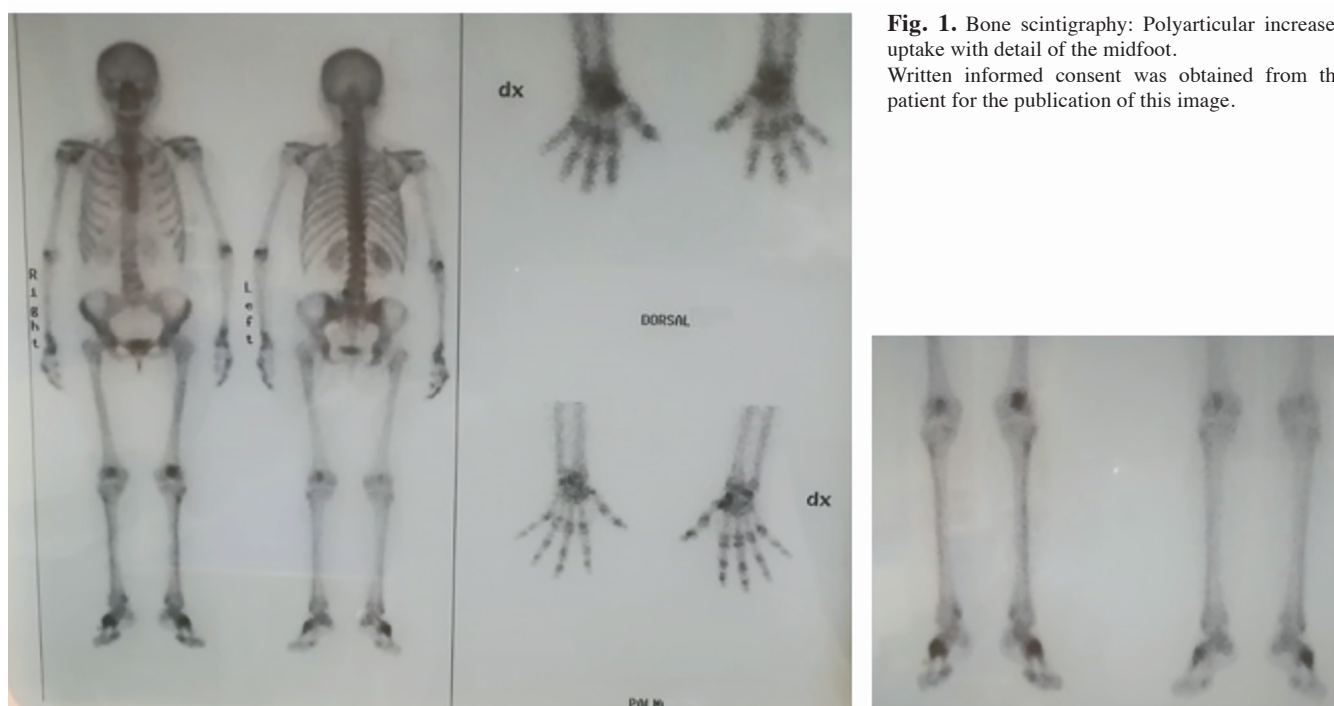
Bone scintigraphy: Polyarticular increased uptake with detail of the midfoot. Written informed consent was obtained from the patient for the publication of this image.
